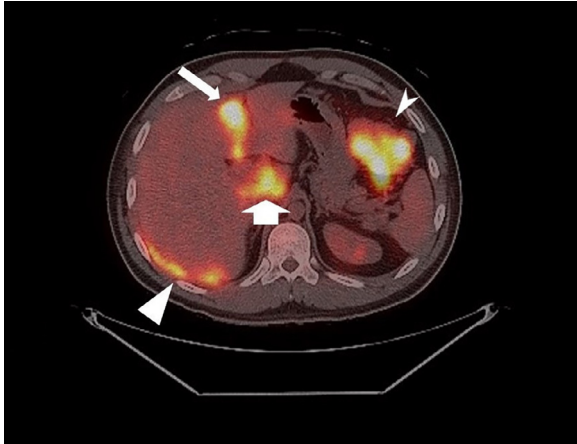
Axial PET/CT showing hypermetabolic abdominal mass (pointed arrow), FDG avid hepatic metastasis (arrow), hepatic surface implants (arrowhead) and porta hepatis lymphadenopathy (thick arrow).
